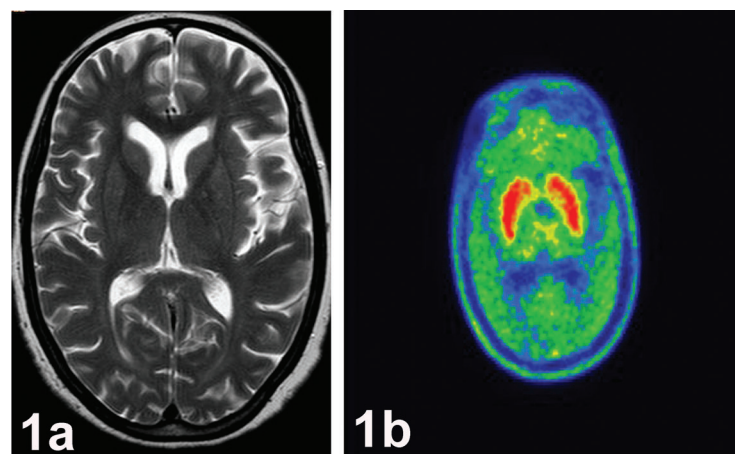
Structural and Functional Imaging of the Brain. (A) T2 weighted magnetic resonance imaging brain shows normal appearing bilateral basal ganglia. (B) 18 F FLUORODOPA (FDOPA) positron emission tomography revealed adequate tracer uptake in bilateral striatum.
